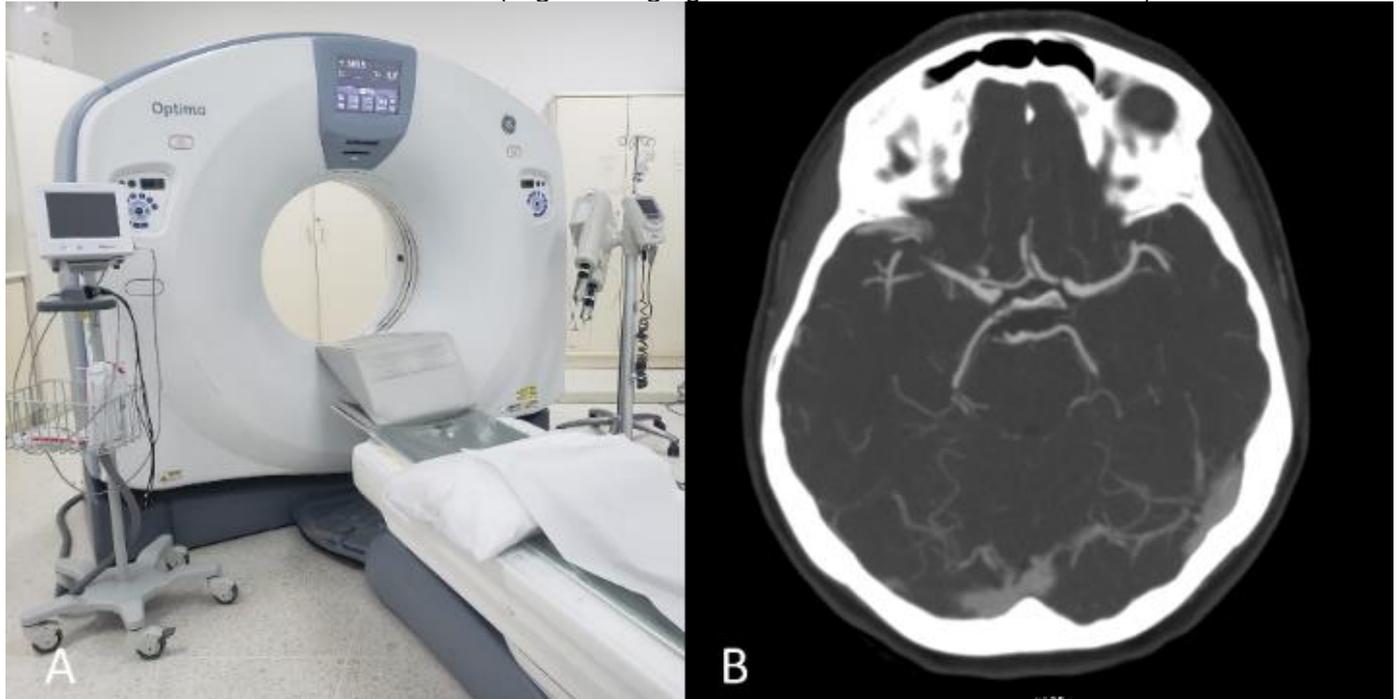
(A) CT General Electric Optima®; and (B) A sample of the DICOM 2D image acquired by this equipment.
